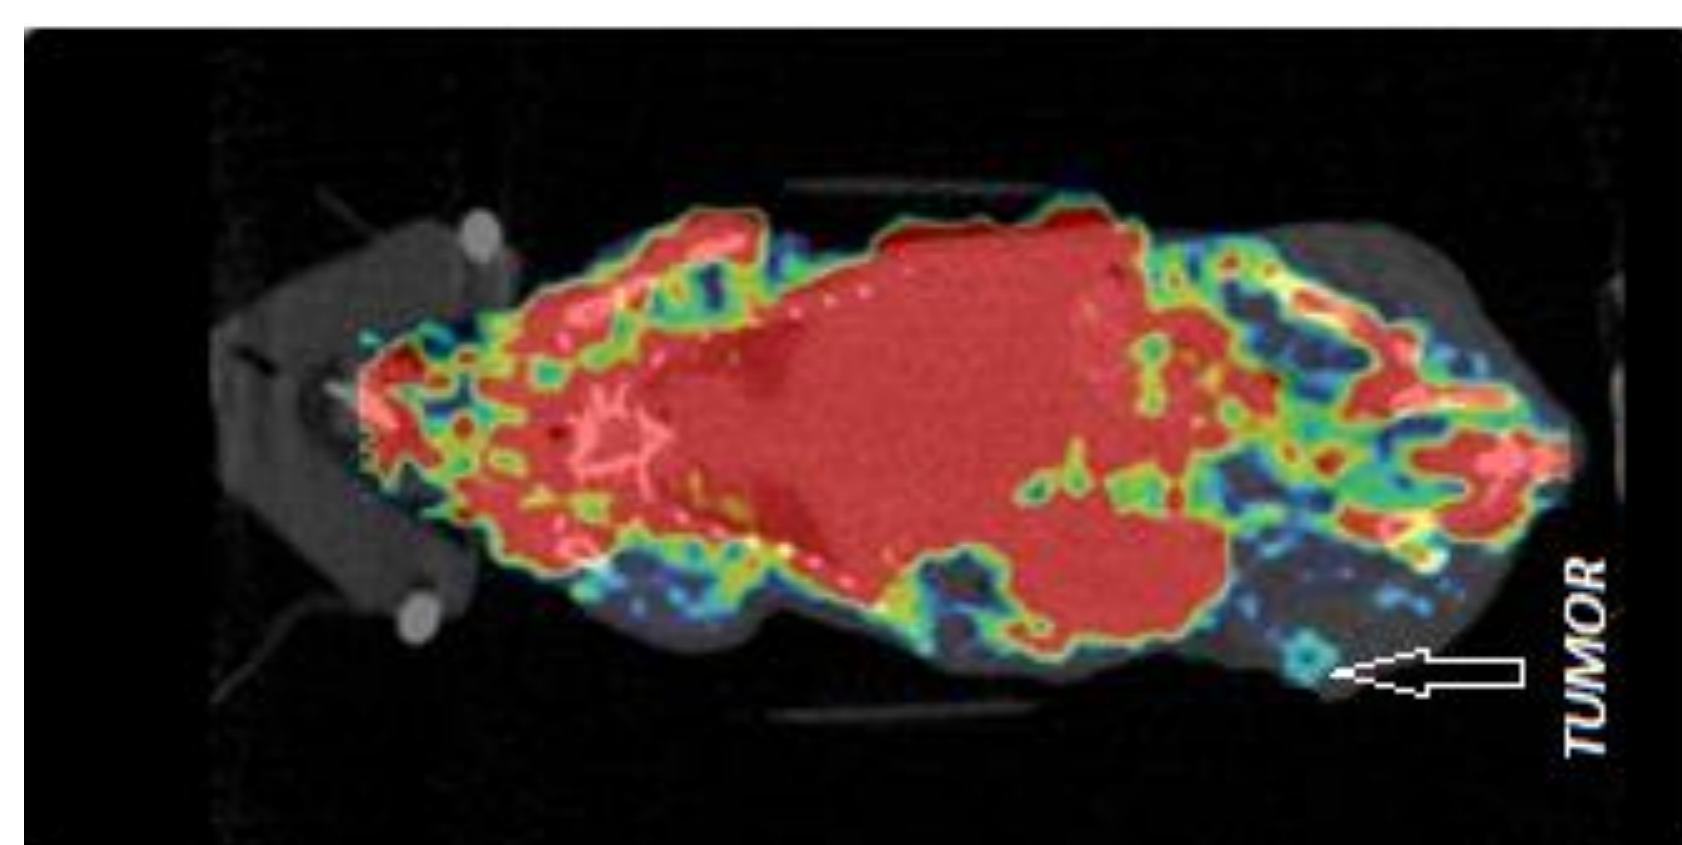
μPET/CT image of PC-3 xenograft.
